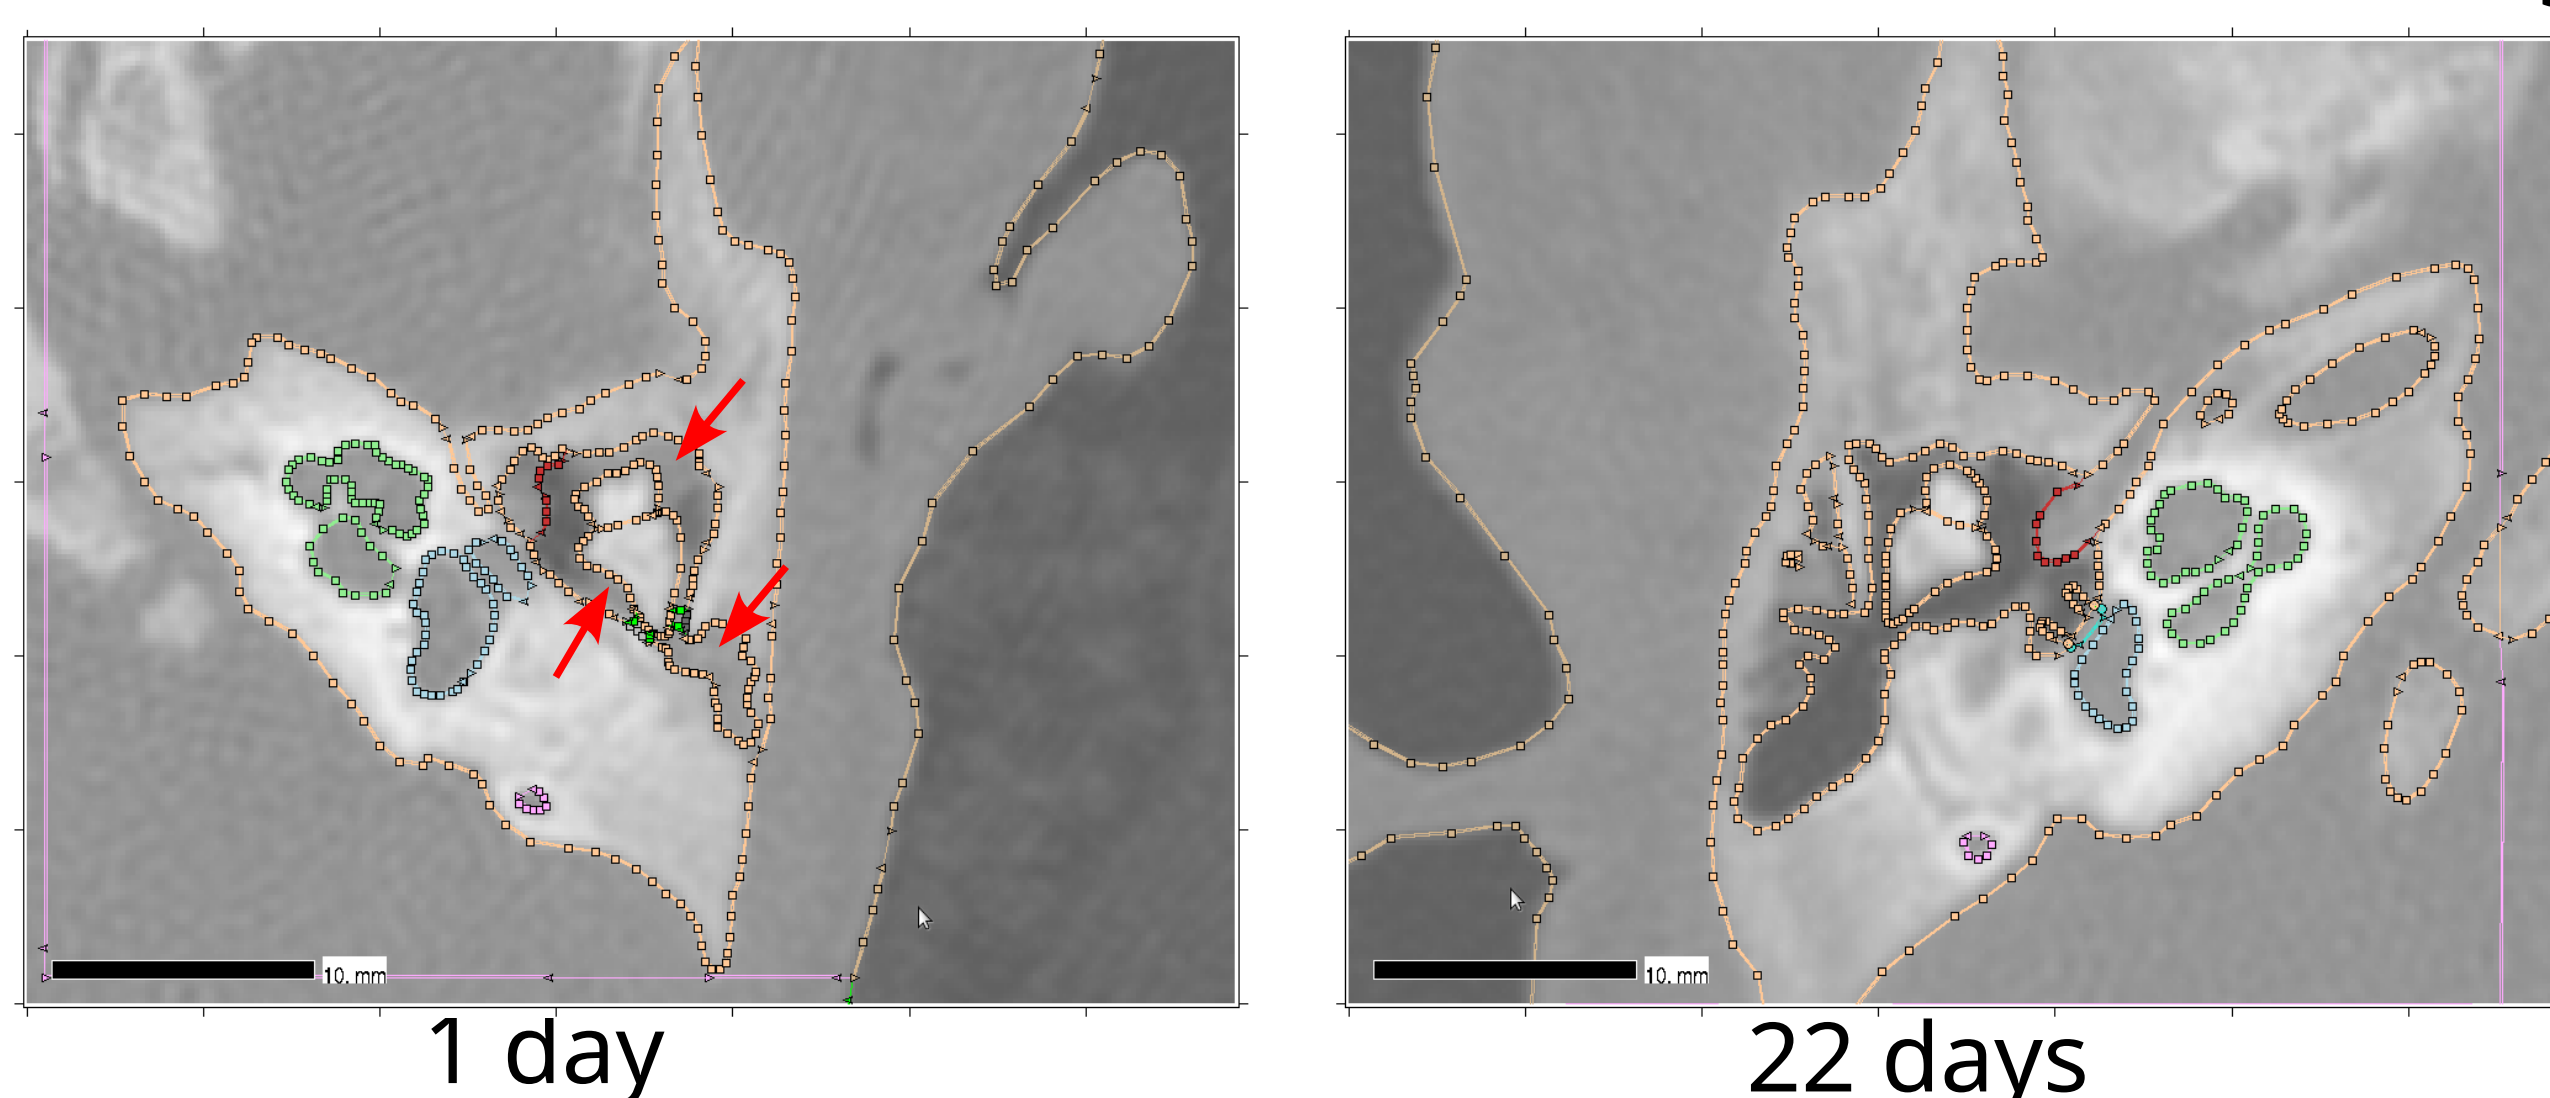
CT slices from 2 newborn ears, viewed in Fie, showing the malleus and incus. Note opacity in air spaces of 1-day-old
